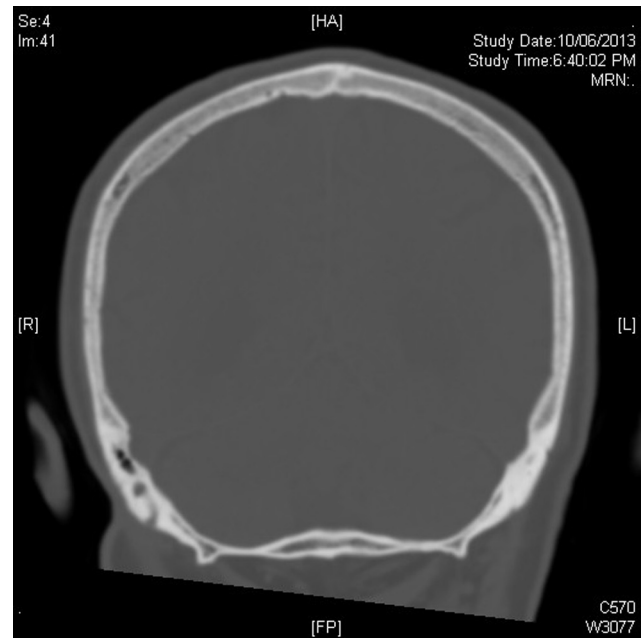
a) Coronal and b) sagittal CT views showing position of mastoid canal and foramen for emissary vein.
